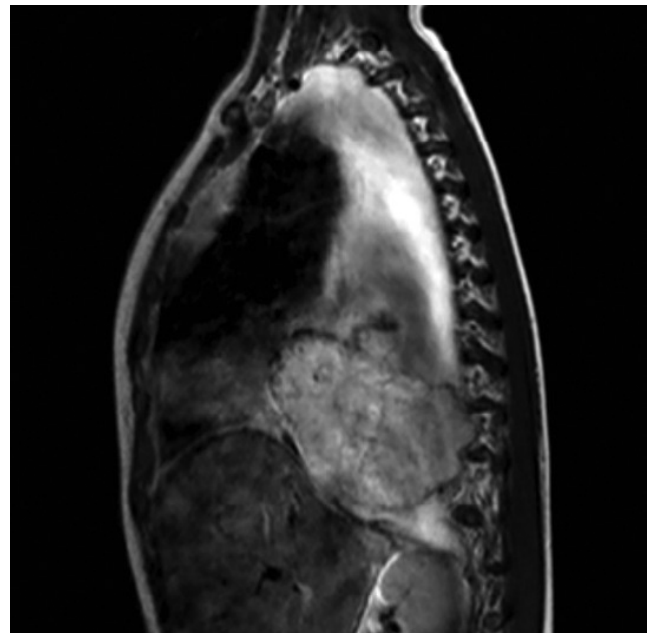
Magnetic resonance image of the chest showing a large right paraspinal soft tissue lobulated mass heterogeneously enhancing with multiple internal necrotic-cystic lesions in the posterior mediastinum extending from the T8 to T12 vertebrae
